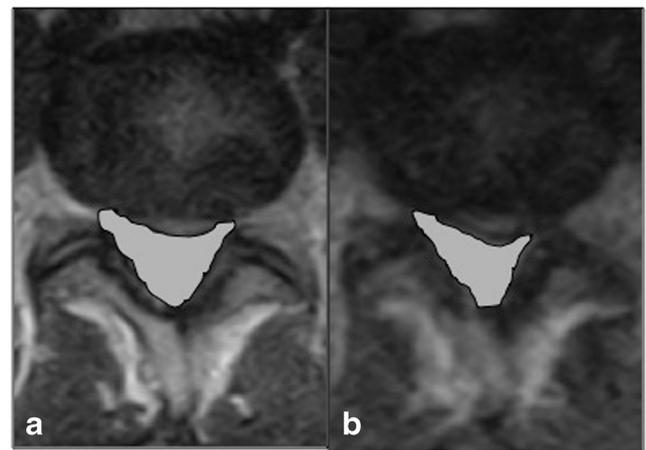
Axial T2-weighted TSE in supine (a) and upright (b) standing. Manual computation of dural sac area (in white) at L4-L5 level is reduced in b
